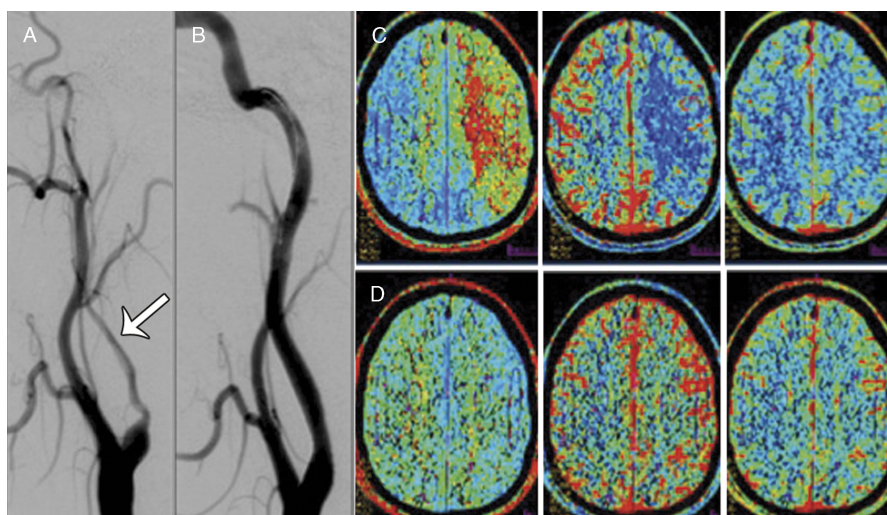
A 30-year-old with expressive aphasia, right hemiparesis after motor vehicle accident. Left common carotid injection digital subtraction angiogram demonstrates long segment vessel irregularity of the left ICA (arrow) compatible with long segment dissection (A). Poststent repair left common carotid injection digital subtraction angiogram (B) demonstrates resolution of left cervical ICA irregularity without disruption of blood flow (C). Axial head CT perfusion images before stenting through the mid cerebrum demonstrate delay in mean transit time and decrease in cerebral blood flow throughout the left cerebral hemisphere with relative preservation of cerebral blood volume, findings compatible with perfusional ischemia and tissue at risk of infarction. Axial head CT perfusion images (D) through the midcerebrum after stent repair of the left ICA demonstrate resolution of previously seen abnormalities in mean transit time and cerebral blood flow throughout the left cerebral hemisphere.
